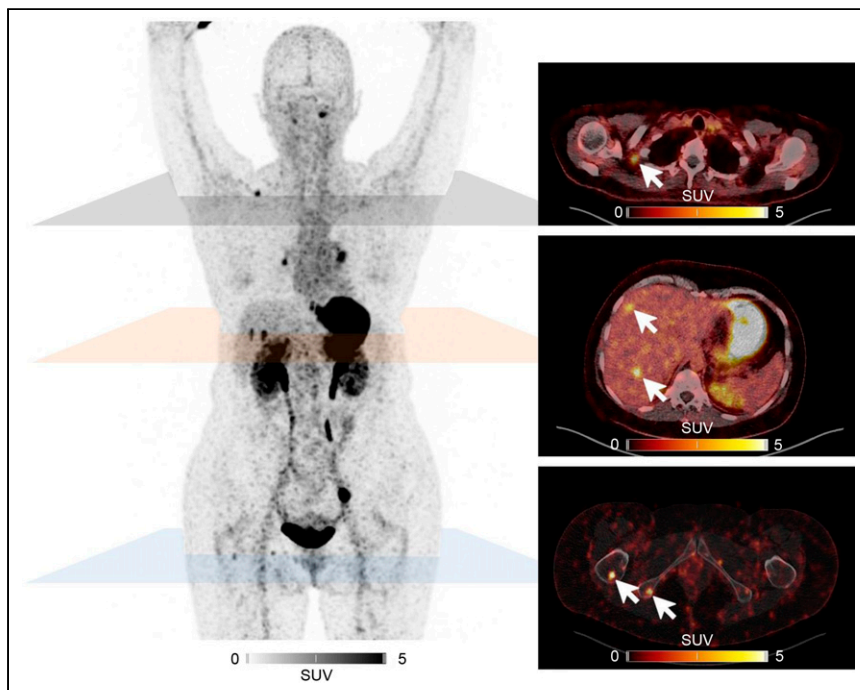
Maximum-intensity projections (left) and fused transaxial sections (right) of 46-y-old female MTC patient undergoing PET/CT at 2 h after intravenous injection of 193 MBq of [^{68}Ga]Ga-DOTA-CCK-66. Several lymph node (e.g., right retroclavicular), liver, and bone metastases (e.g., right femur and right ischium) could be detected (arrows).
